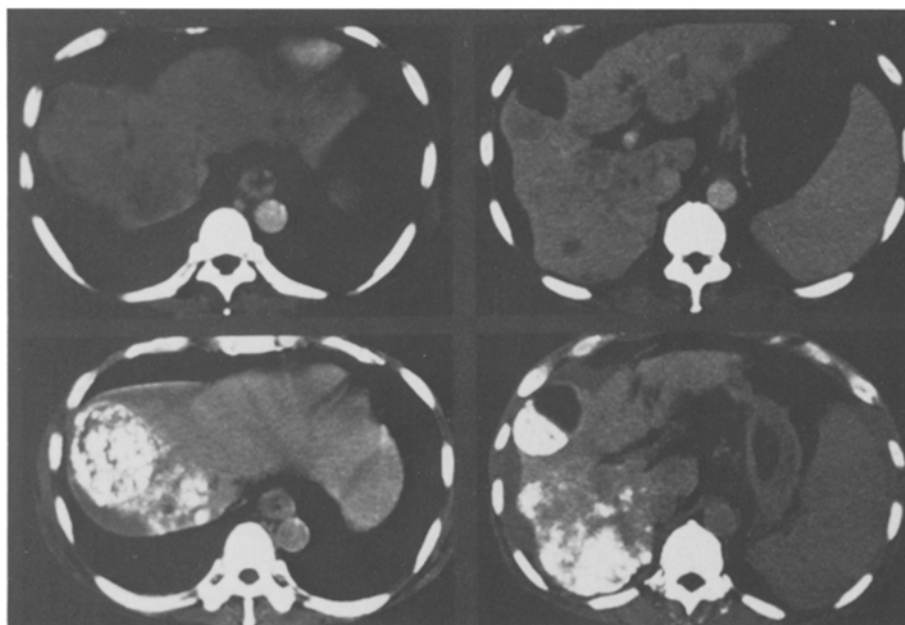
A 58-year-old man with multiple bone metastases. CT scans taken before (*upper row*) and 1 week after (*lower row*) the intra-arterial alcoholization. Multiple HCC masses are visible disseminated in the liver. Some of the nodules are exophytic on the liver surface and others are of very low density, suggestive of spontaneous tumor necrosis. CT scans in the *lower row* show dense deposition of Lipiodol in the tumors, with a high risk of rupture
